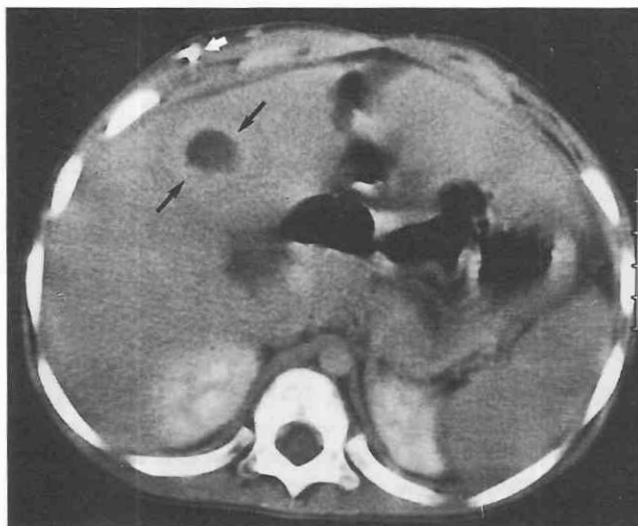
Pyogenic abscess. Contrast-enhanced CT image shows a low-attenuation abscess in the left lobe of the liver with peripheral rim enhancement (arrows). Incidentally noted is a ventriculoperitoneal shunt tube (open arrow) in the subcutaneous tissues of the anterior abdominal wall.
